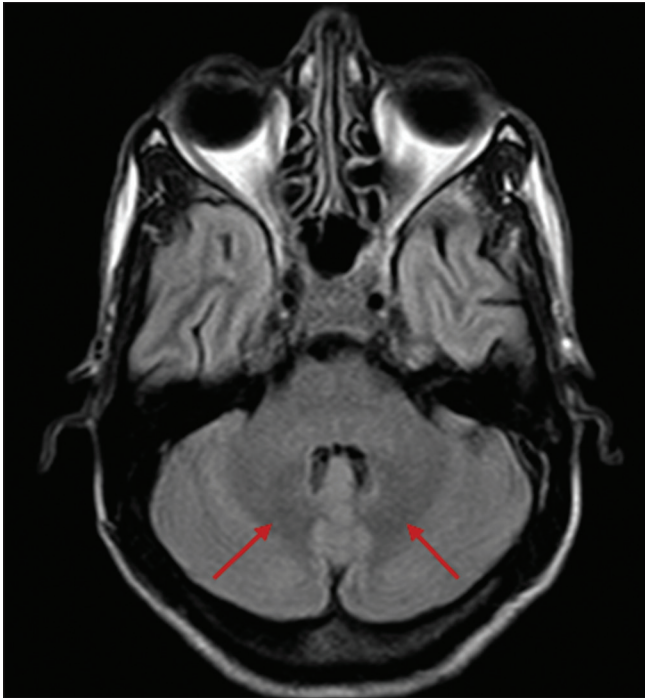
Axial FLAIR image shows resolved hyperintense signal in both dentate nuclei of cerebellum
